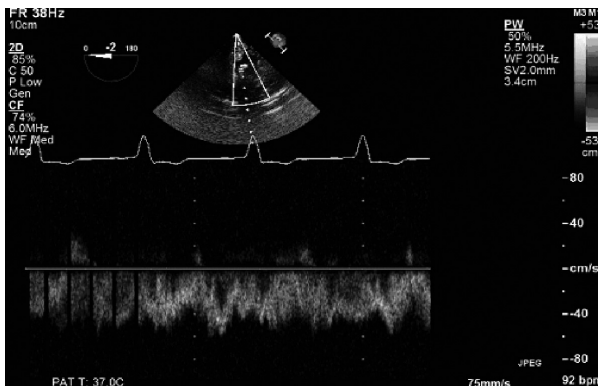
PW Doppler of the inflow cannula in the LV apex.
